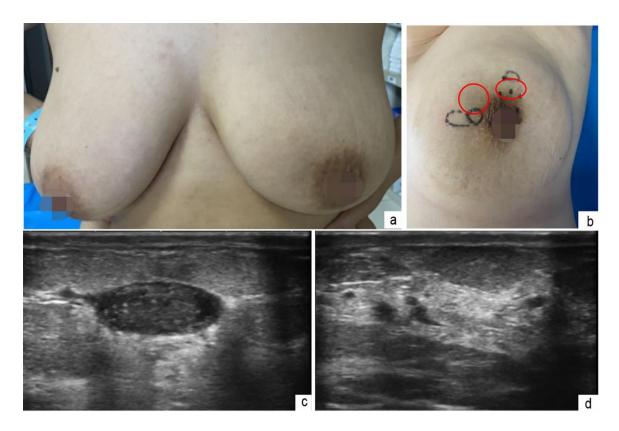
Self-limited stage. a, b Granulomatous lobular mastitis in a 33-year-old woman with a painful mass of 6 weeks' duration in the upper inner quadrant of the left breast, without nipple retraction. c, d Hypoechoic masses were detected by ultrasound at the direction of 10 o'clock (3.5 cm \times 0.9 cm) and 12 o'clock (0.5 cm \times 0.4 cm, 0.3 cm \times 0.2 cm, 0.4 cm \times 0.2 cm)
